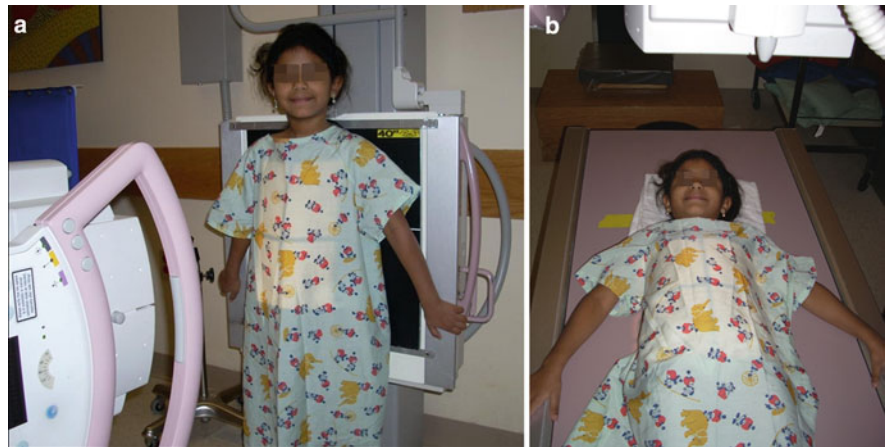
Seven-year-old girl. School age children are typically cooperative for supine (a) and upright (b) views of abdominal radiographs
